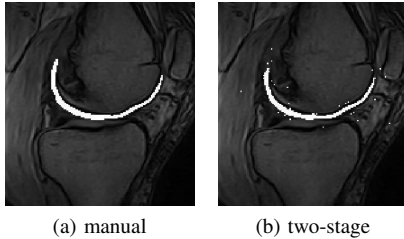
Slice taken from a 3D MRI scan segmented by (a) a radiologist and (b) our two-stage method. The slice was chosen to demonstrate that, although the proposed method outperforms the state-of-the algorithm [6], there is still room for improvement by (simple) post-processing.
